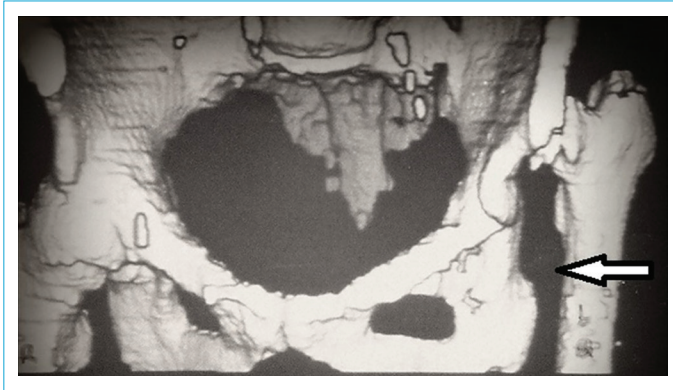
Three-dimensional computed tomography reconstruction performed in our clinic for a 35-year-old female patient. Visible are a hypoplastic shallow acetabulum and a high-lying femoral head on the left side.
